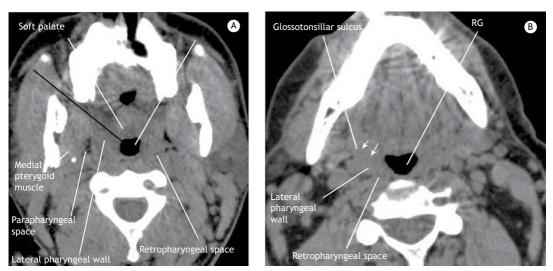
Axial CT images of the retropalatal (RP) and retroglossal (RG) regions (A and B, respectively). The lateral pharyngeal walls are delimited medially by air. The black line in A represents the anterior aspect of the medial border of the lateral pharyngeal wall. The glossotonsillar sulcus (arrows) marks the anterior limit of the lateral pharyngeal wall at the RG level (B). The lateral pharyngeal wall is delimited laterally by the parapharyngeal space and posteriorly by the retropharyngeal space.
